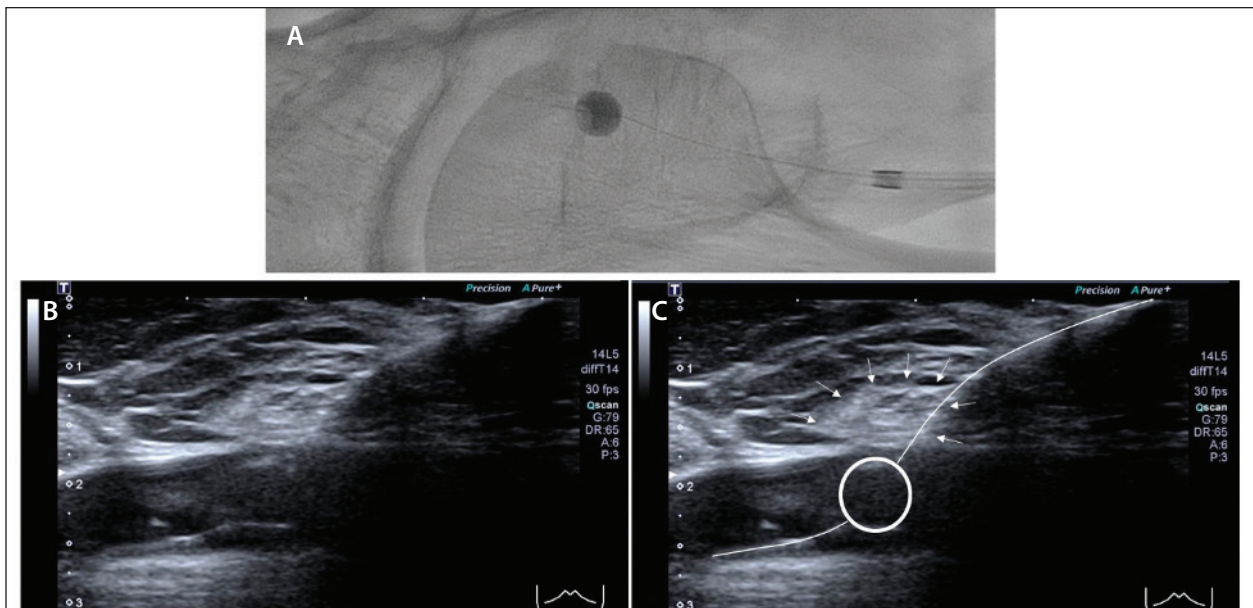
Fluoroscopic (A) and sonographic (B, C) images of the MYNX CONTROL™ VCD intravascular balloon during vascular closure. Arrows show the PEG cap.
